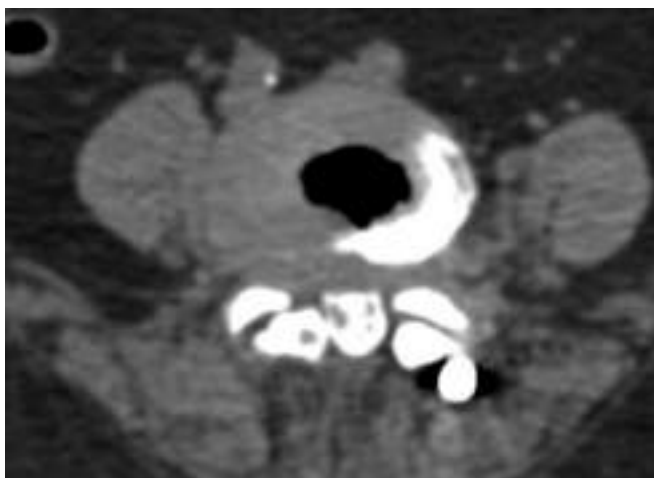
Axial CT images showing vacuum phenomenon
